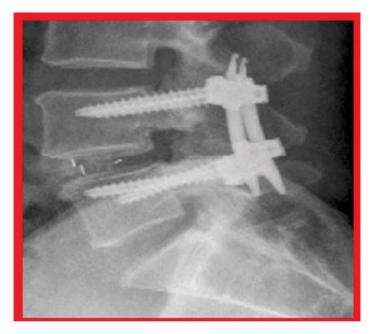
Lateral radiograph of the lumbar spine: Fusion of the degenerative L4-5 anterolisthesis shown above in Figure 6. (Courtesy of Minimally invasive versus traditional open transforaminal lumbar interbody fusion for the treatment of low-grade degenerative spondylolisthesis: a retrospective study. Sci Rep 10, 21851 (2020). https://doi.org/10.1038/s41598-020-78984-x)
